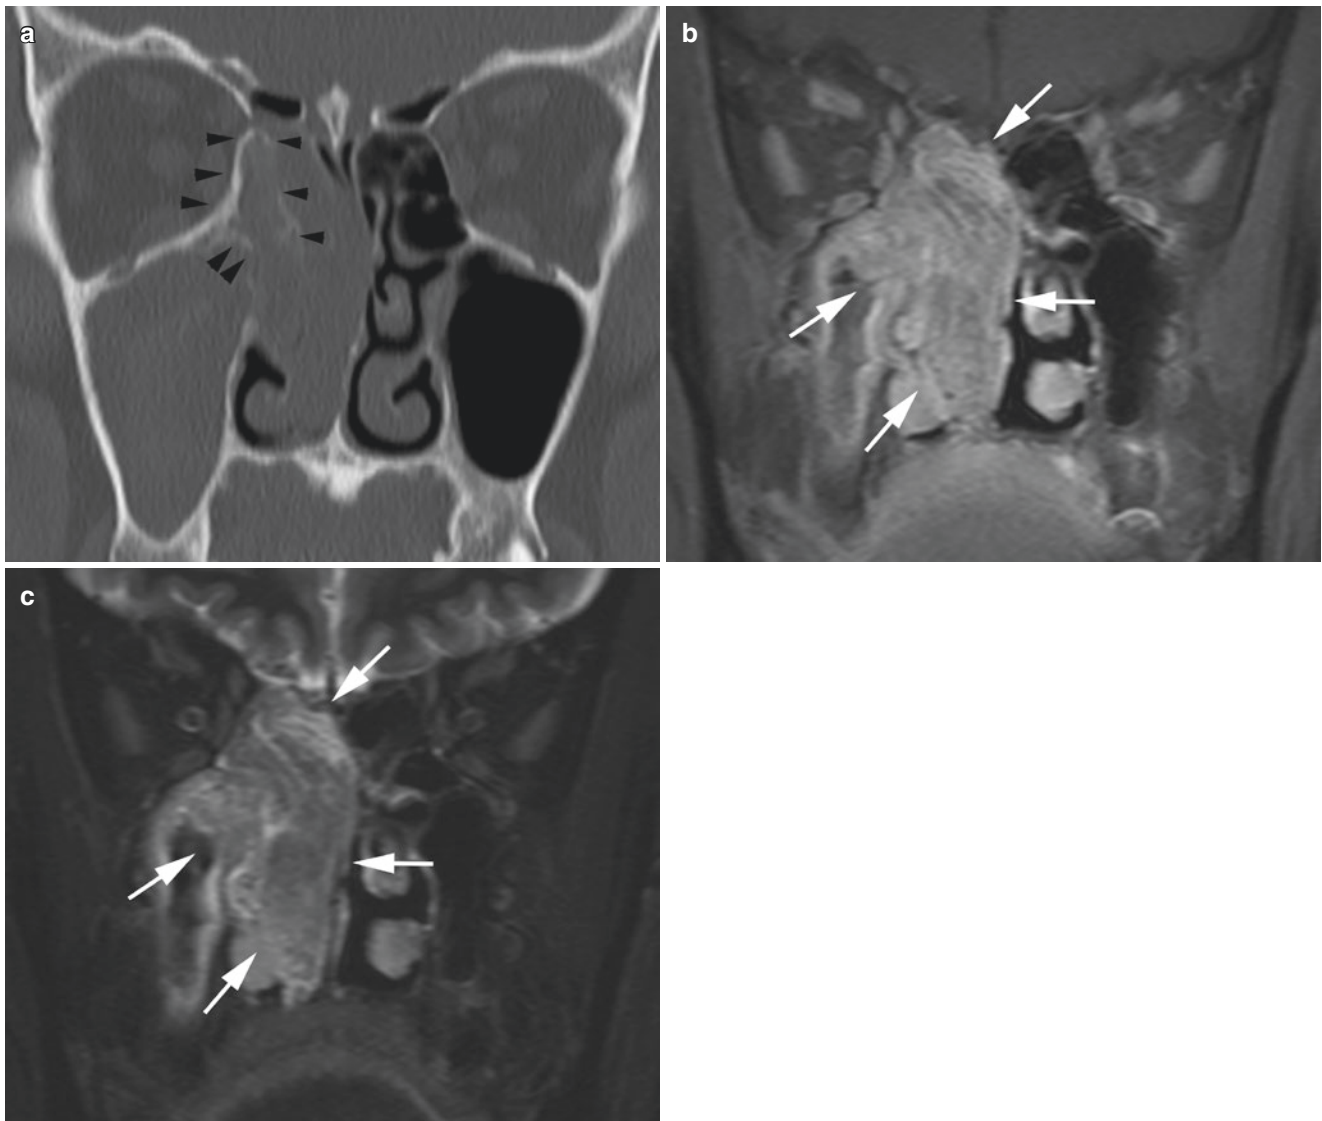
Inverted papilloma. (a) Bone CT. (b) Coronal Gd-enhanced T1-weighted image. (c) Coronal T2-weighted fat-suppressed image. A tumorous lesion is found in the right nasal cavity. Gd contrast T1-weighted (b) and T2-weighted (c) images show convoluted cerebriform appearance, with striping present centered on the lamina papyracea (arrows). The nasal septum is compressed by the tumor and deviates
